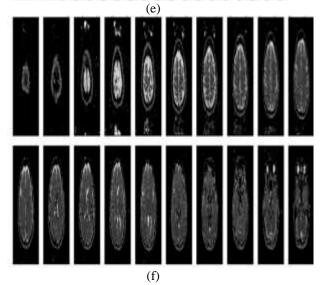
Evaluation of critical MRI quality control (MRQy) metrics across multiple participants (MSB-08583) with the highest values.
